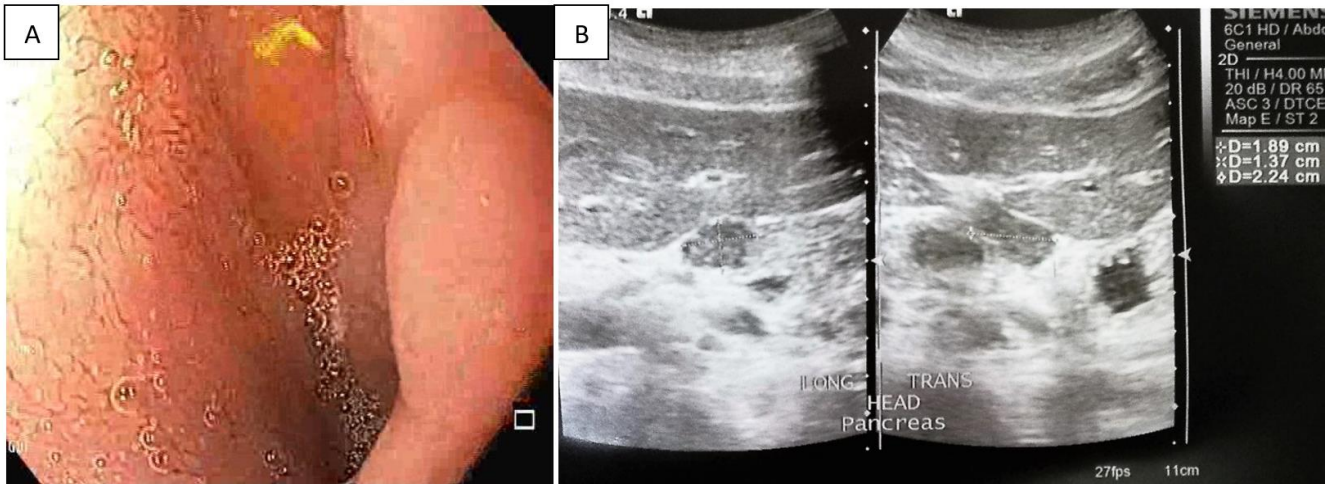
Repeat upper endoscopy (A) and whole abdominal ultrasound (B) after 3 months of anti-Koch's therapy
